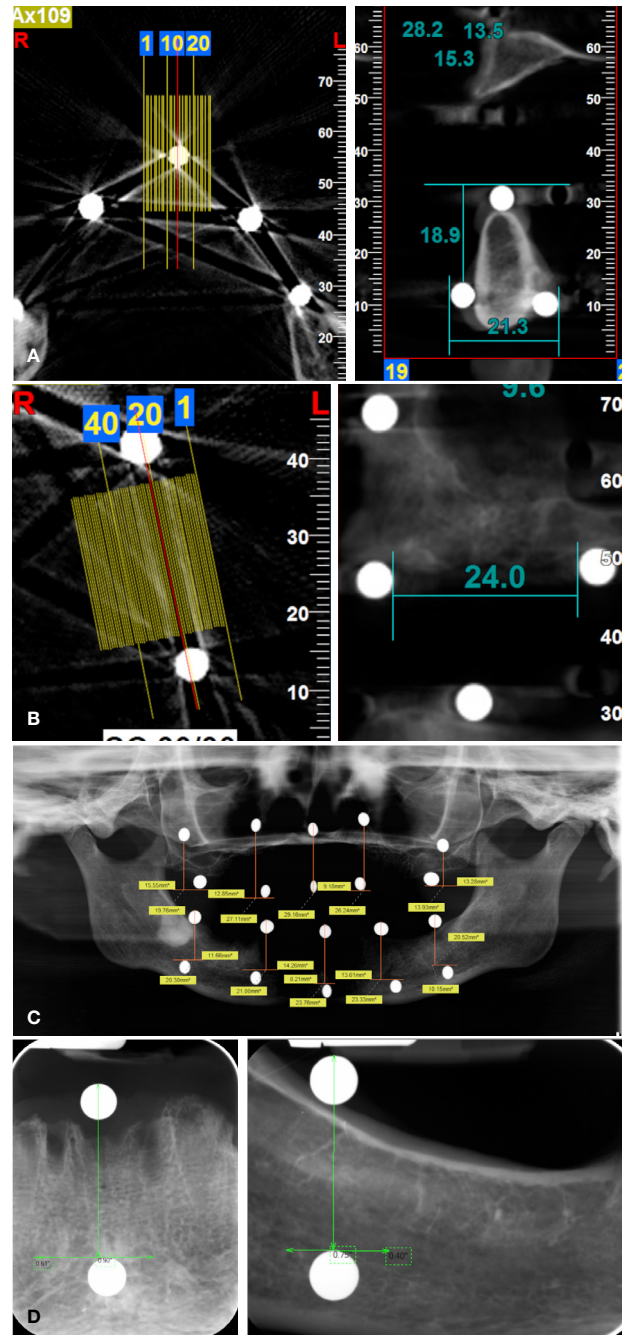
Virtual measurements captured on CBCT volumes (A&B), panoramic (C), periapical (D) radiographs.
